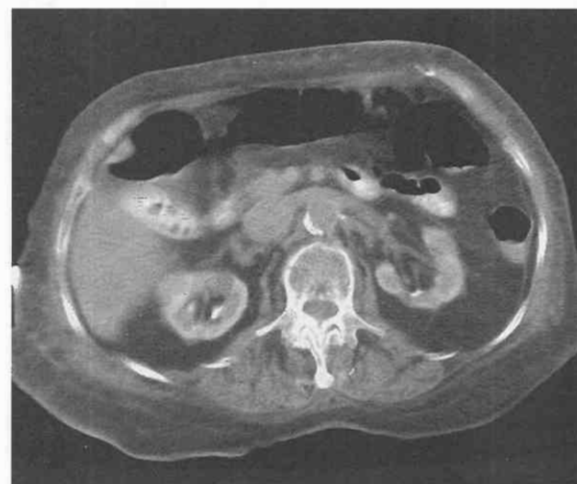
CT scan of patient with renal failure shows concentration of contrast material in the gallbladder, which permits visualization of radiolucent gallstones.
